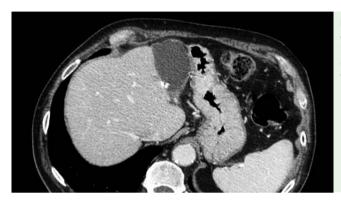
Cross-sectional computed tomography image of the abscess (arrow) located between the remnant liver and the stomach.
